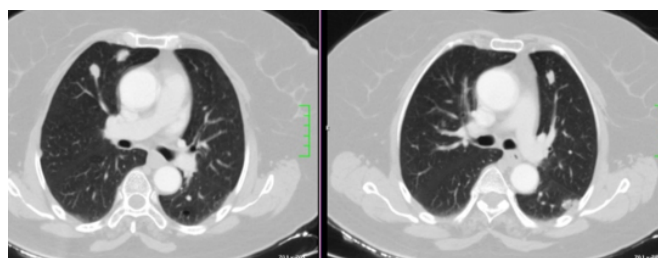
Preoperative thorax CT showing bilateral nodular lesions.
